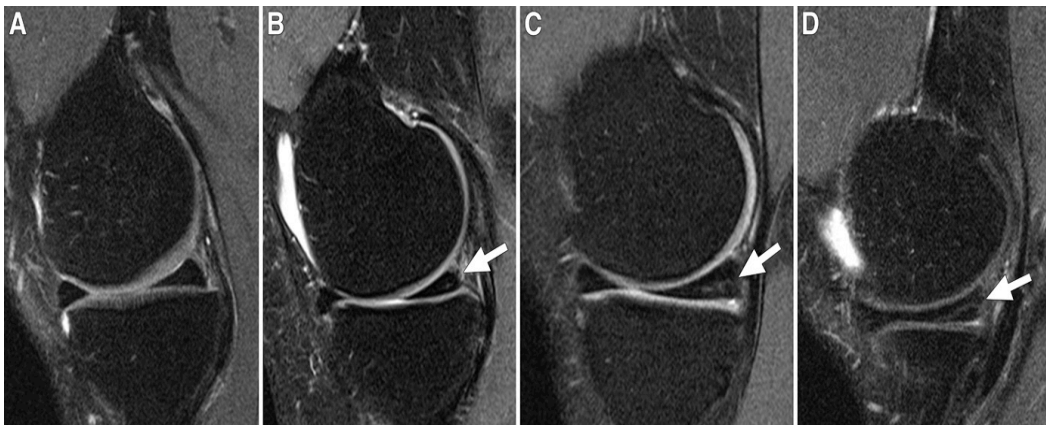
Sagittal intermediate-weighted fat-saturated MR images of the medial meniscus from four study participants demonstrate different grades of intrameniscal signal intensity in the posterior horn. A, Normal morphology of the medial meniscus. B, Focal grade 1 signal intensity (arrow) in the posterior horn of medial meniscus. C, Linear grade 2 signal intensity (arrow) not extending to the surface of the meniscus. D, Linear grade 3 signal intensity (arrow) involving the inferior surface of the posterior horn on only one image section. *From Kumm et al. Natural History of Intrameniscal Signal Intensity on Knee MR Images: Six Years of Data from the Osteoarthritis Initiative. Radiology. 2016.*
